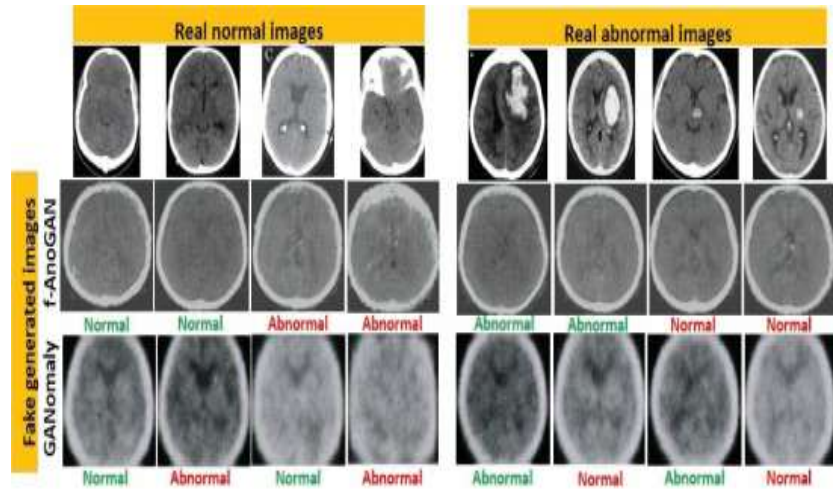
Examples of the Head-CT dataset (the first row) and their reconstructed images by f-AnoGAN (the second row) and GANomaly (the third row) along with their predicted labels.
